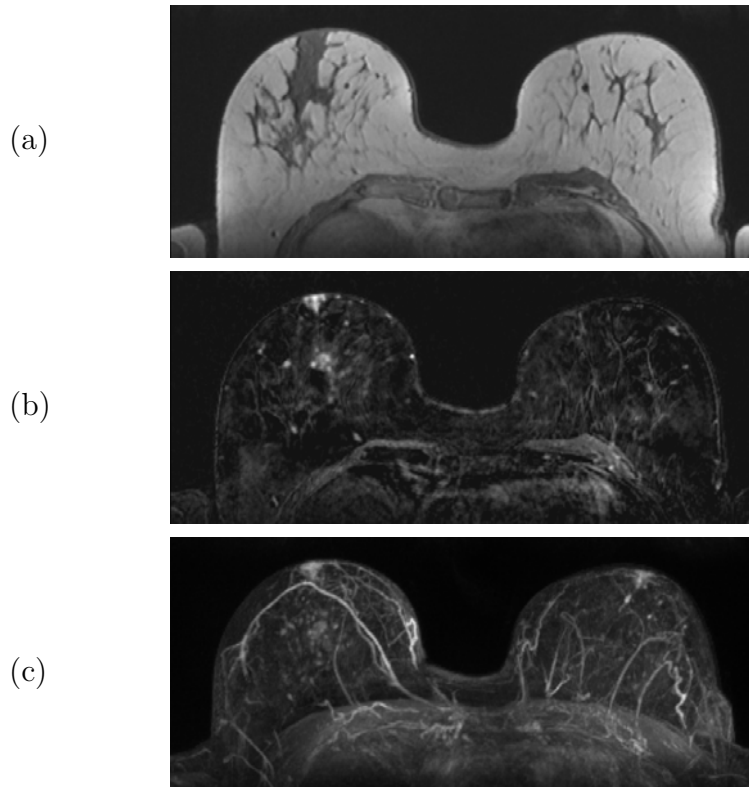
(a) Axial slice of the pre-contrast T1-weighted volume and (b) corresponding axial slice extracted from the subtraction volume computed at the first post contrast time point. Maximum intensity projection image of the subtracted volume is shown in (c).
